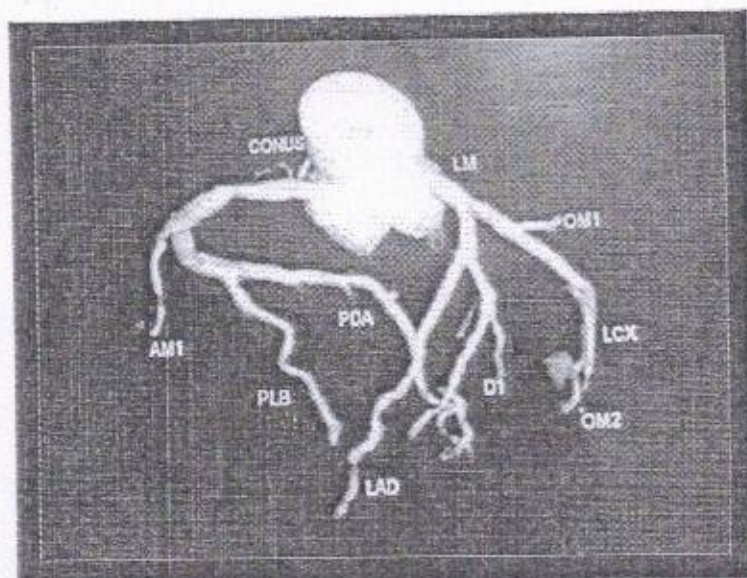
Showing Coronary artery tree in 64 CTA
